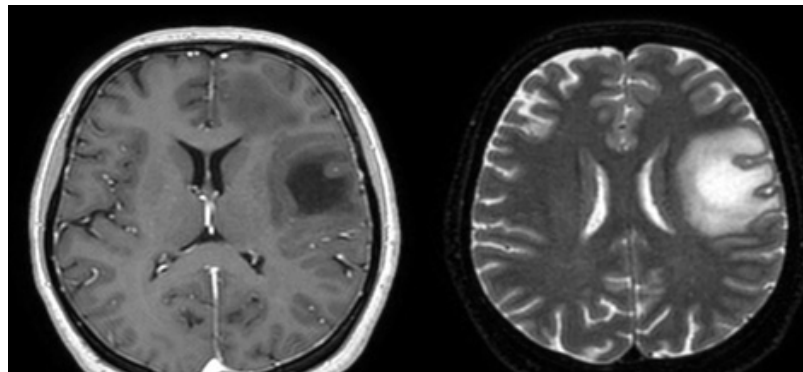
MRI brain (T1-weighted, T2-weighted)
